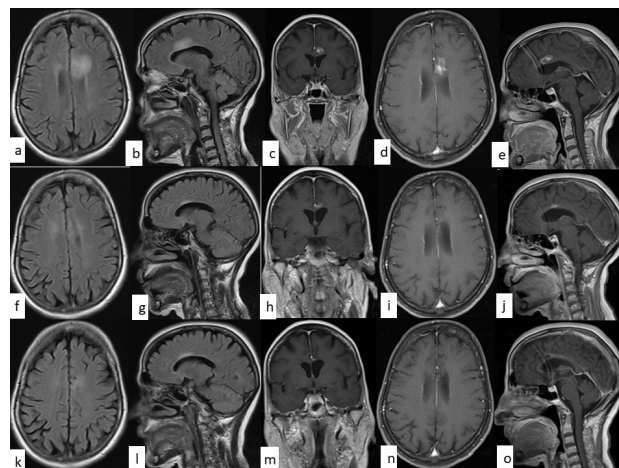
Follow-up MRIs demonstrating gradual regression of lesions. December 2019: Periventricular lesion with high intensity in FLAIR (a, b) and homogeneous enhancement on GAD-enhanced T1W images (c–e); decreased enhancement compared with previous scan. August 2020: Subtle periventricular FLAIR hyperintensity (f, g) with mild enhancement on GAD-enhanced T1W images (h–j); marked regression of lesion. June 2022: Subtle periventricular FLAIR hyperintensity (k, l) without enhancement on GAD-enhanced T1W images (m–o); near-complete regression.
